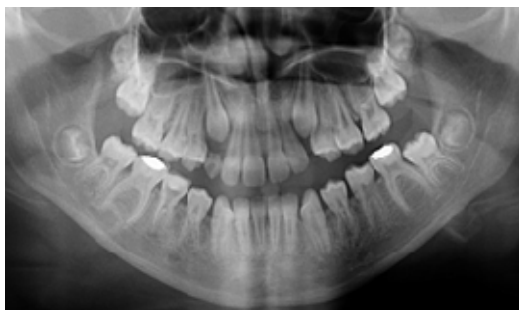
Panoramic radiograph of the case at the baseline.
